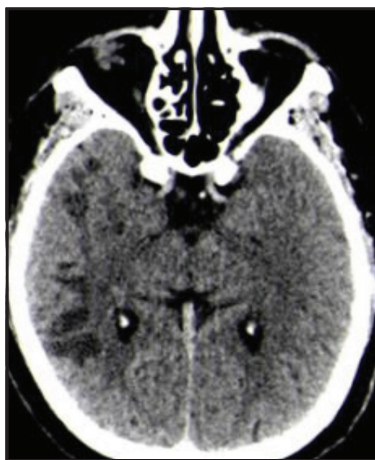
CT brain showing patchy infarcts in the right MCA territory.
